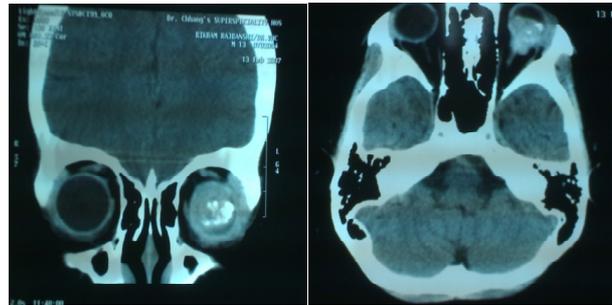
CT scan of orbit and brain showing intraocular calcification.(before enucleation)
